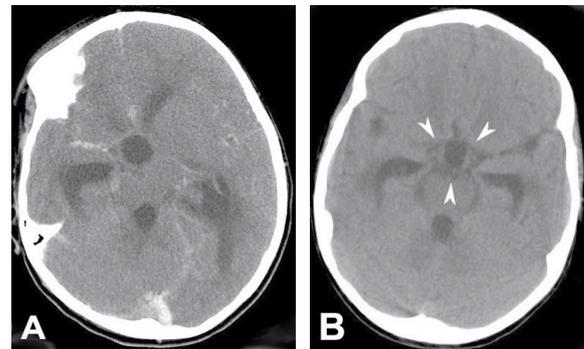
An axial Computerized Tomography (CT) of the brain at the fourth ventricle level shows communicating hydrocephalus, figure A was obtained before and figure B was after surgical placement of a ventricular drain which is not seen at this level.
